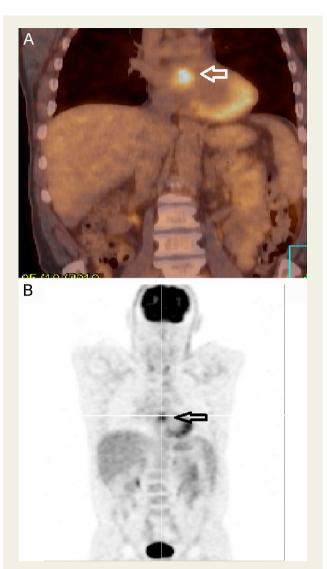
18 FDG PET/CT scan in 2010 with intense uptake at the aortic valve (with extension into the roof of the left atrium) on coronal combined PET/CT image (A) and coronal MIP (maximum intensity projection) image (B) (Arrow).
